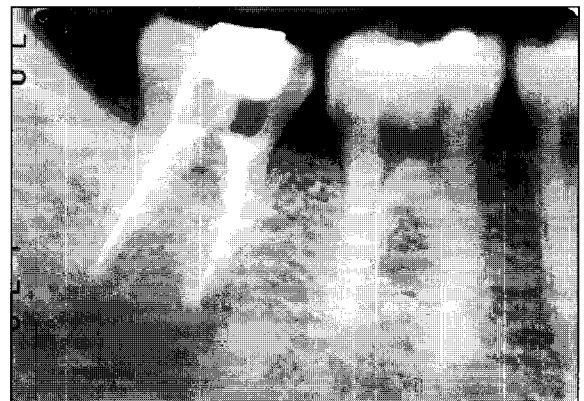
Preoperative radiograph, inappropriate root canal treatment and periapical radiolucency at root apex of mandibular right second molar are seen.
